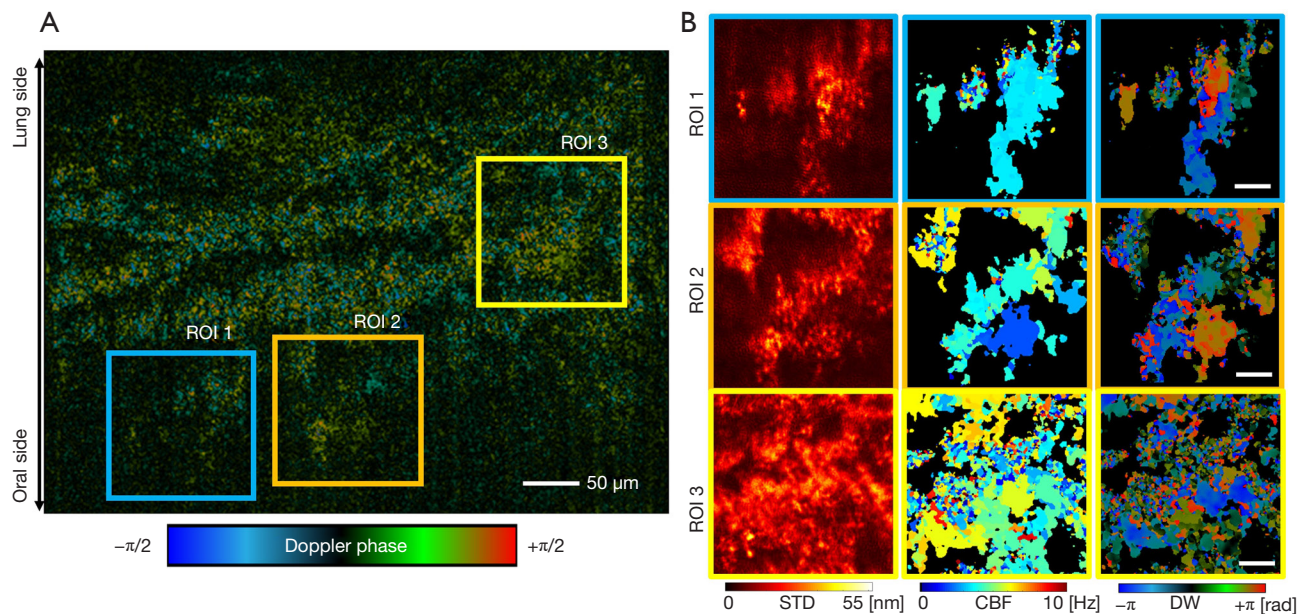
Analysis results of a rabbit tracheal tissue explant. (A) Phase-resolved Doppler image of the tracheal tissue. (B) Phase-resolved enhanced dynamic analysis of selected ROIs. Scale bars indicate 20 μm . ROI, region-of-interest; STD, standard deviation; CBF, cilia beating frequency; DW, dynamic wavefront.
